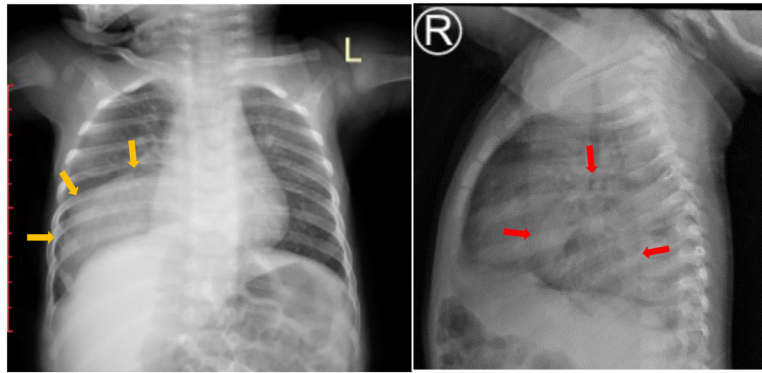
Frontal and lateral chest radiograph shows a well-defined, homogeneous radiopaque mass (yellow arrow) with an obtuse angle in the right paracardial area, located posterior to the heart (red arrow).
